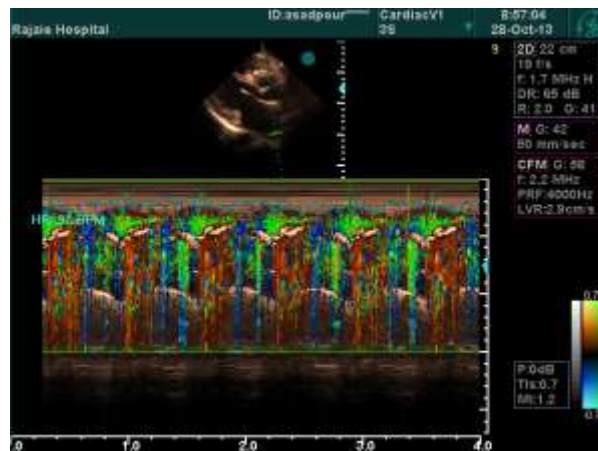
Color M-mode in transthoracic echocardiography, showing a continuous flow in systole and diastole, which is due to concomitant ventricular septal defect and ruptured sinus of Valsalva
